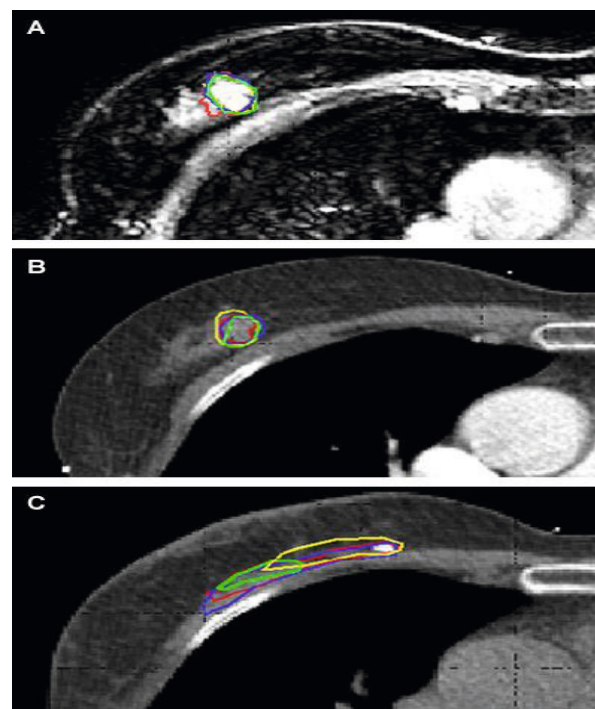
3D GTV delineations of 4 different observers in one patient in the transverse plane at (a) preoperative CE-MRI, (b) preoperative CE-CT, and (c) a clinical example of a postoperative CT.
